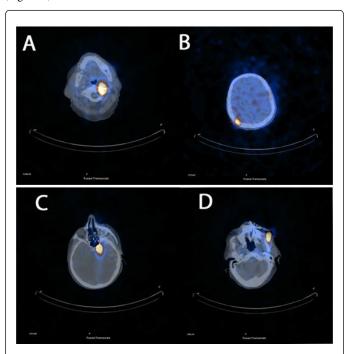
SPECT/CT post-RAI therapy findings-Focal radioactive iodine uptake areas respectively located: at the left anterior arch of the C1 (A); at the right parietal region of the skull (B); near the left sphenoid region (C); at the soft tissue of the left mandibular region (D).
